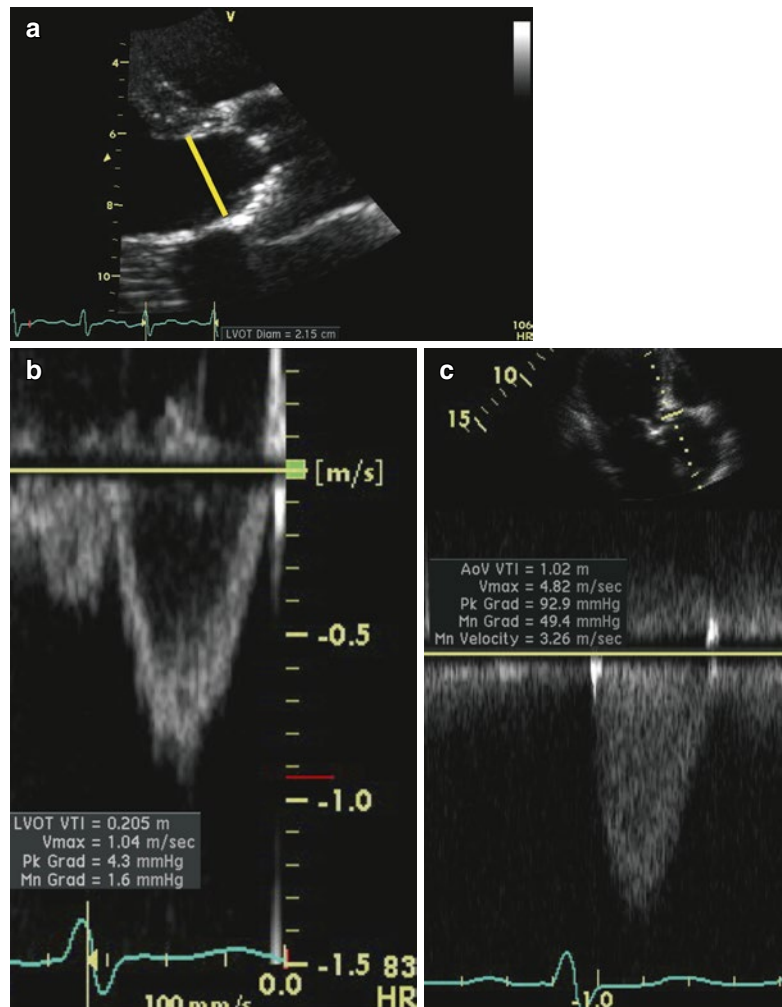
Echocardiographic information used in the calculation of aortic valve area (AVA) using the continuity equation. Panel (a) is the recording of the LVOT diameter and panel (b) the LVOT Doppler flow pattern with measurement of velocities. Panel (c) shows the aortic stenosis jet velocity by CW and the tracing of the spectrum. The calculated AVA is seen to be 0.73 cm² once all required measurements are completed
